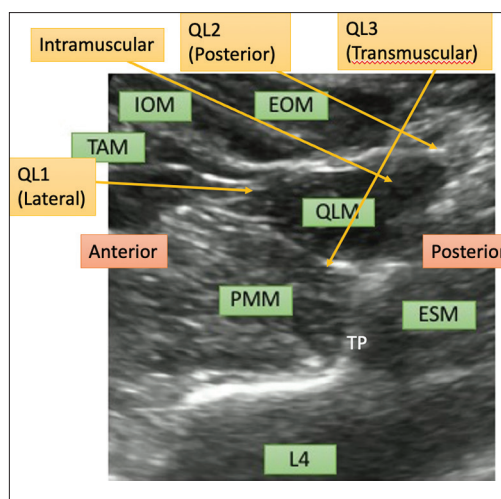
Ultrasound-guided QLB (EOM—External Oblique muscle, IOM—Internal Oblique Muscle, TAM—Transversus Abdominis Muscle, PMM—Psoas Major Muscle, ESM—Erector Spinae Muscle, L4–L4 vertebra)
